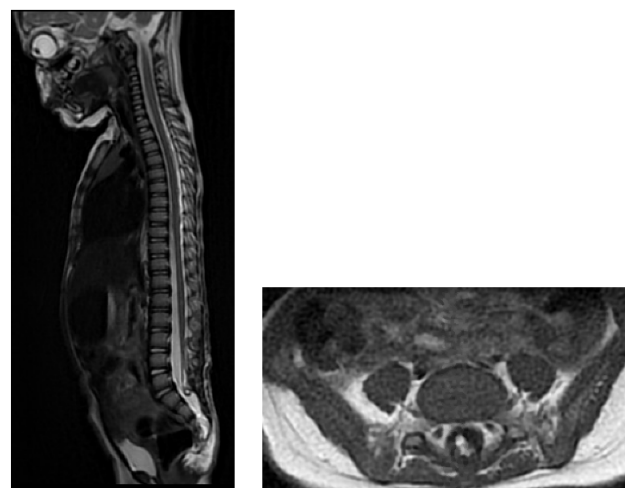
MRI findings at 4-month post op follow up with complete clinical recovery
